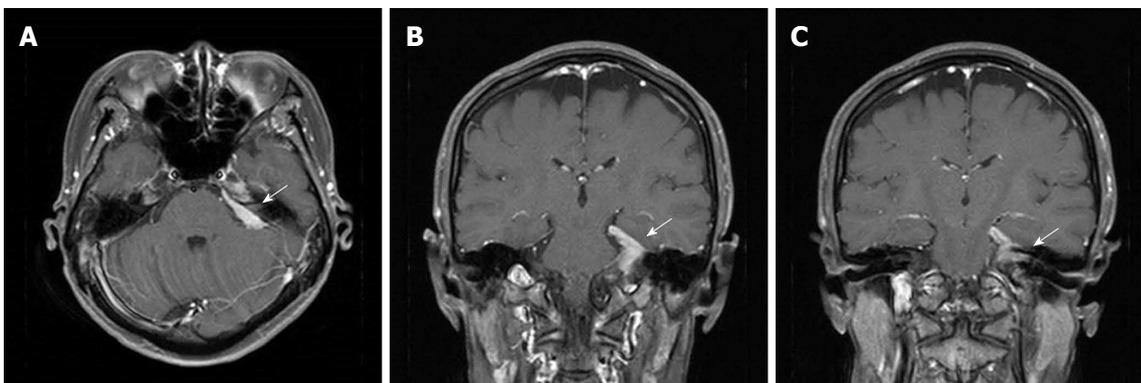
Magnetic resonance imaging of the brain. On axial (A) and coronal (B and C) contrast-enhanced T1-weighted imaging of the brain MRI, a homogenous, enhancing dural mass is visible at the left cerebellopontine angle cistern (A and B) invading the left trigeminal nerve and internal auditory canal (C). MRI: Magnetic resonance imaging.
